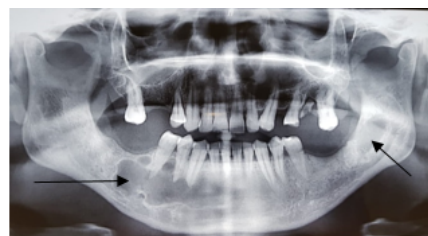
Orthopantomogram showing radiolucent cysts in right and left mandible.
